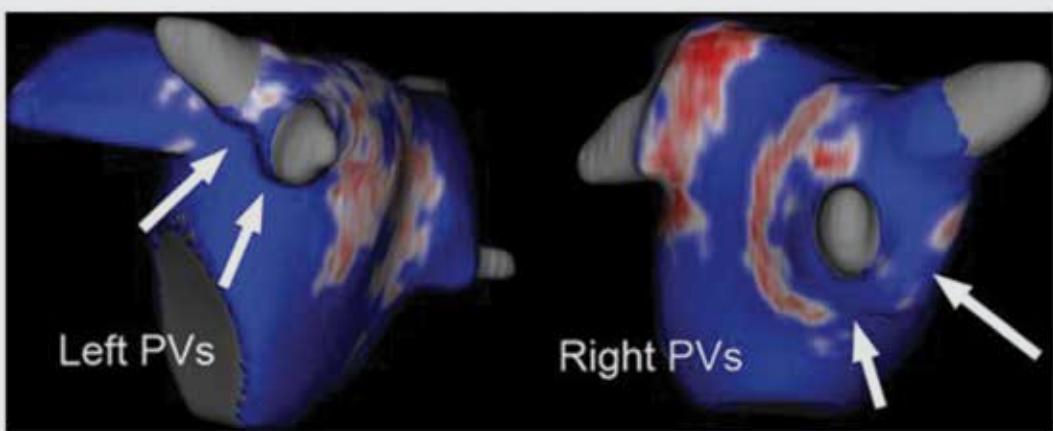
Late gadolinium enhanced cardiovascular magnetic resonance images of the left atrium following pulmonary vein ablation for atrial fibrillation. The arrows point to gaps in the pulmonary vein encirclement. Reproduced with permission from Gal and Marrouche.²³
